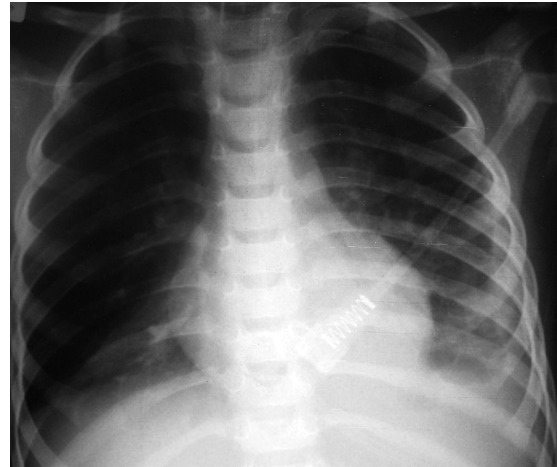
Control chest radiograph shows a significant resolution of pulmonary infiltrates post surfactant therapy.
